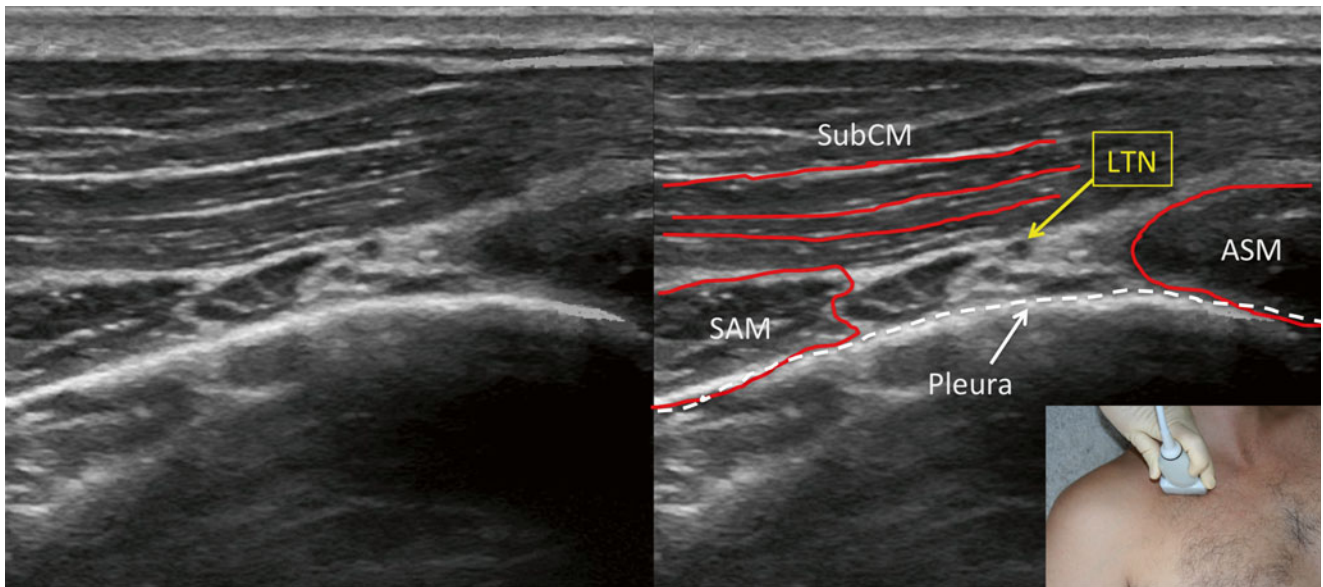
Ultrasound identification of the long thoracic nerve at the subclavicular region. *LTN* long thoracic nerve, *SAM* serratus anterior muscle, *SubCM* subclavicularis muscle, *ASM* anterior scalene muscle (Image courtesy of Andrea Trescot, MD)
